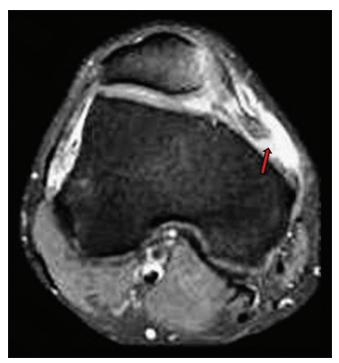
Magnetic resonance imaging T2W of right knee joint showing: Patellofemoral ligament tear at femoral attachment (red arrow); Medial patellar retinaculum rupture
